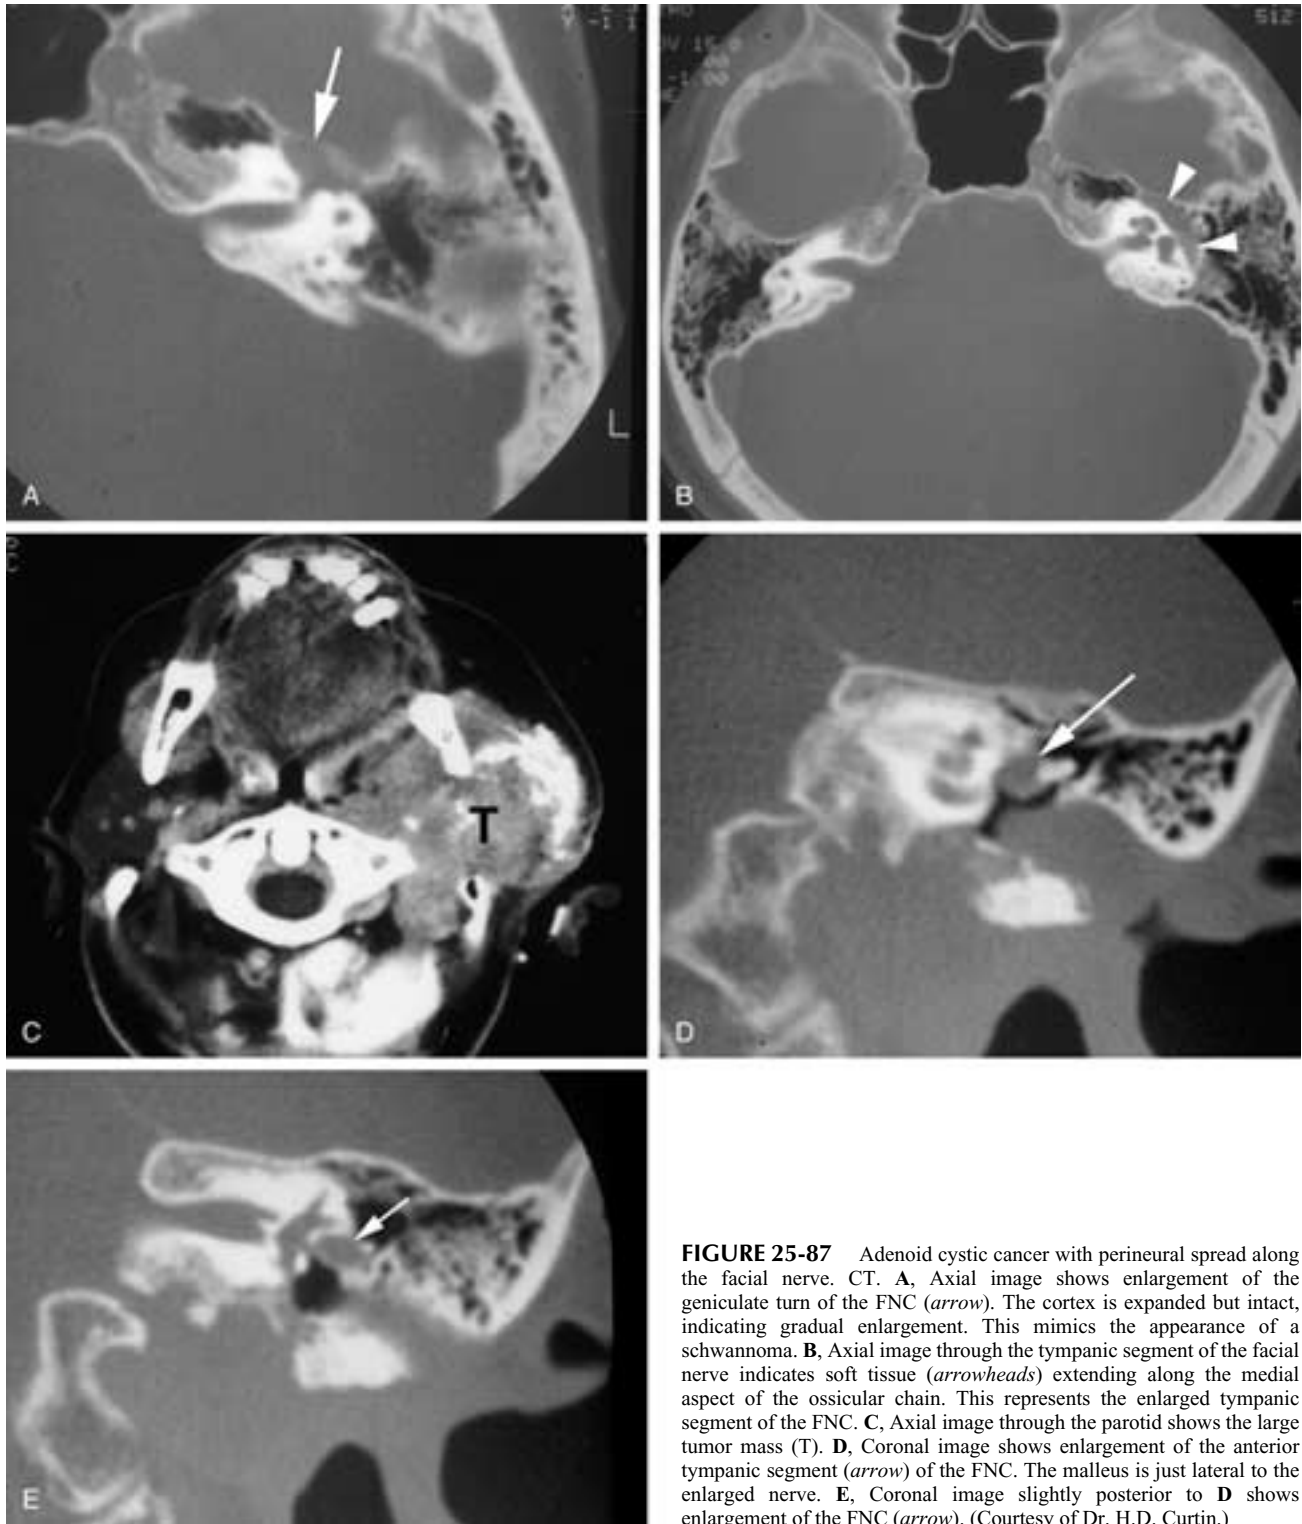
Adenoid cystic cancer with perineural spread along the facial nerve. CT. A, Axial image shows enlargement of the geniculate turn of the FNC (*arrow*). The cortex is expanded but intact, indicating gradual enlargement. This mimics the appearance of a schwannoma. B, Axial image through the tympanic segment of the facial nerve indicates soft tissue (*arrowheads*) extending along the medial aspect of the ossicular chain. This represents the enlarged tympanic segment of the FNC. C, Axial image through the parotid shows the large tumor mass (T). D, Coronal image shows enlargement of the anterior tympanic segment (*arrow*) of the FNC. The malleus is just lateral to the enlarged nerve. E, Coronal image slightly posterior to D shows enlargement of the FNC (*arrow*). (Courtesy of Dr. H.D. Curtin.)
